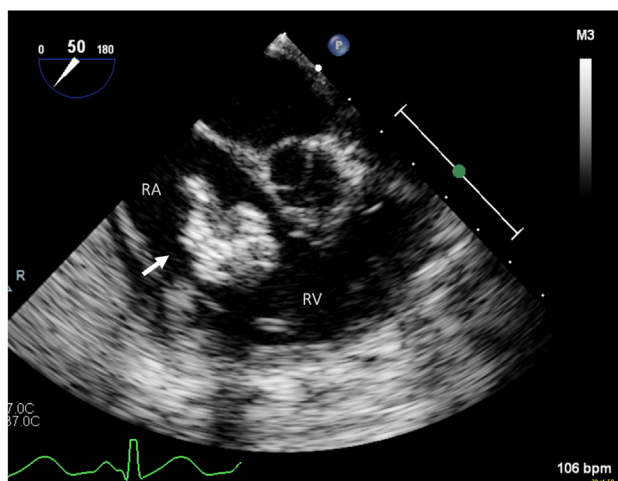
Two-dimensional transesophageal echocardiogram, mid-esophageal, basal short-axis RV outflow tract (50°) diastolic view, demonstrates a normal aortic valve and a large, mobile echobright mass (arrow) in the RA.
